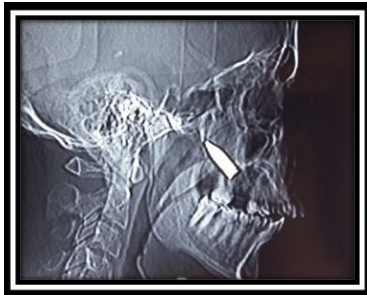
Plain radiograph showing the bullet lodged in the maxilla.
